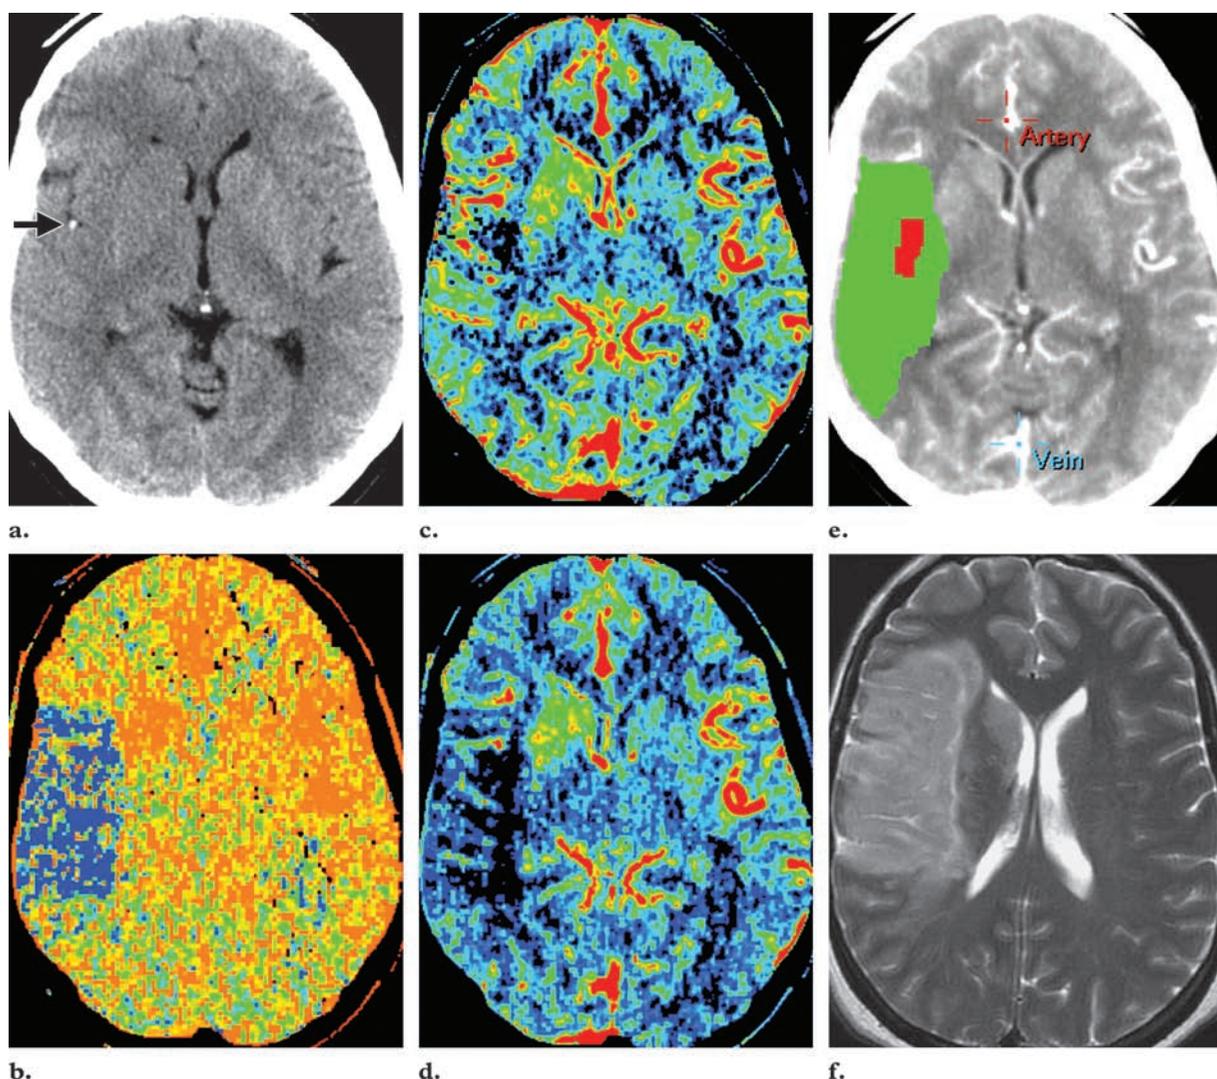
Acute stroke (6 hours evolution) in a 46-year-old woman with left hemiplegia. (a) Nonenhanced CT scan shows the dot sign (arrow) in the right MCA, loss of right-sided gray matter–white matter differentiation, and obscuration of the basal ganglia. (b–e) Perfusion CT maps of MTT (b), CBV (c), and CBF (d) and a summary map (e) show altered MTT and CBF in the right frontotemporal area, suggestive of ischemia, and a reduced subcortical area with decreased CBV, suggestive of an infarcted core. Note the area of increased CBF and CBV in the right caudate and lenticular nucleus, representing the first stage of brain ischemia (compensatory supply with cerebrovascular reserve). (f) Follow-up axial T2-weighted MR image shows a hyperintense right frontoparietal area and caudate nucleus related to final infarction in the ischemic area (both decreased and increased flow areas at perfusion CT), which resulted because no treatment was performed.
